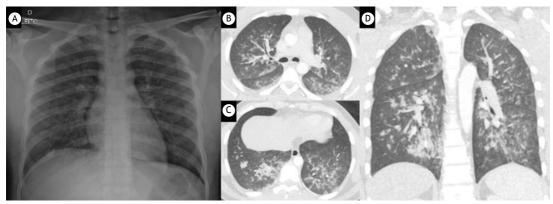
In A, Anteroposterior chest radiograph (bedside) demonstrated subtle ill-defined opacities, more evident in the lower right lung field. In B, C, and D, pulmonary CT angiography images (lung window) in axial (B and C) and coronal (D) planes revealed several small, sometimes coalescing, consolidative opacities associated with ground-glass opacities affecting all of the lobes in both lungs, predominantly in peribronchovascular regions, more extensive in the lower lobes. These findings are consistent with pulmonary edema (in this case, negative pressure pulmonary edema). It is worth mentioning that the exam was negative for pulmonary embolism.
